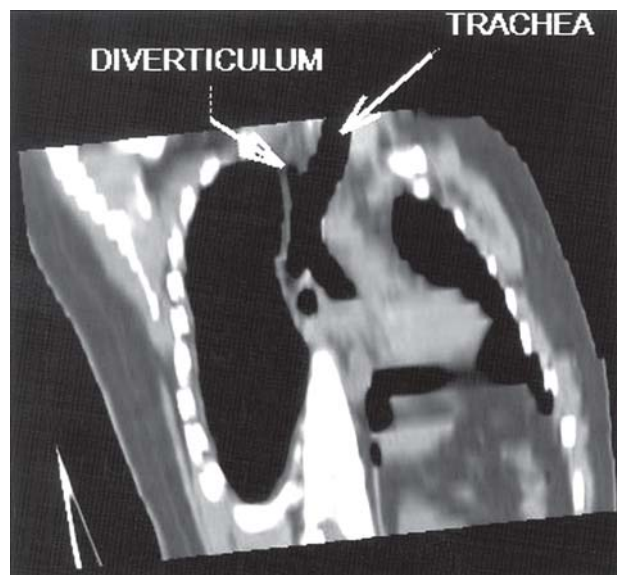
Coronal section of contrast enhanced computed tomography showing a diverticulum (white arrow) arising from the right posterolateral wall of the trachea.
